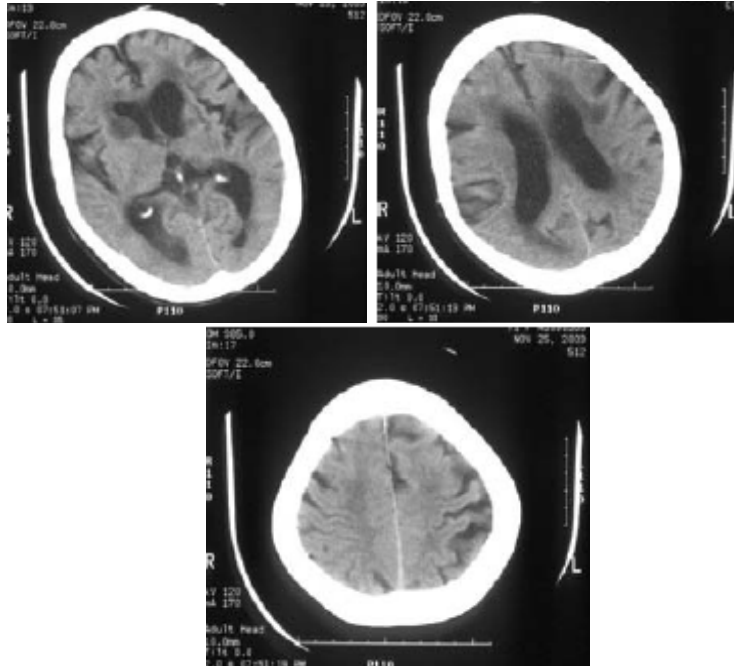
Subcortical vascular dementia. Figure 2a. Computed Tomography
